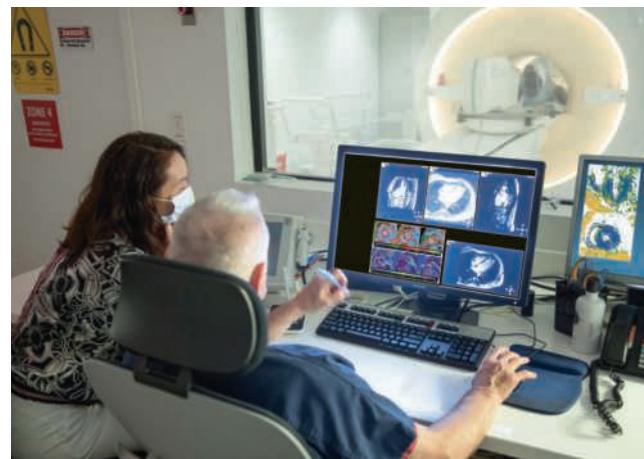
Photos showing a volunteer using the ergometer in an MRI scanner while Dr. Kwon and a colleague view the resulting images on a monitor.
